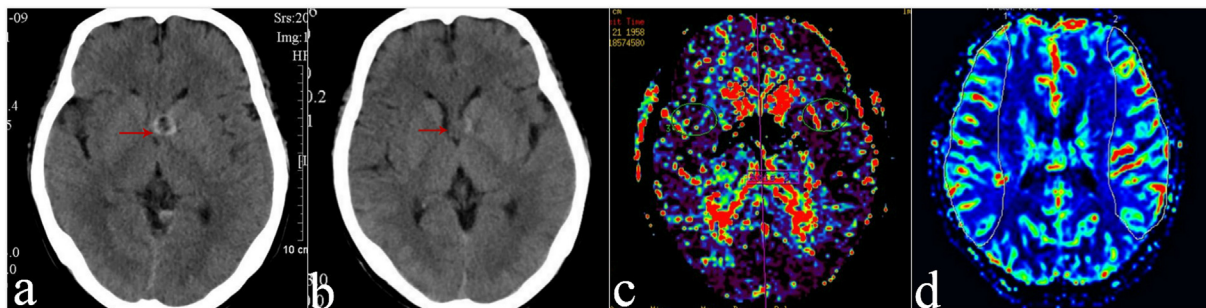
Imaging results of plain cranial scan and perfusion CT in a patient with minimal intracranial hemorrhage. (a): 24 h after operation, CT suggested that the left basal ganglia was removed; (b):72 h later, CT showed that the area of microcircular hemorrhage was less than that before; (c–d): perfusion CT suggested that there was no significant difference in mean blood perfusion between the two hemispheres.
